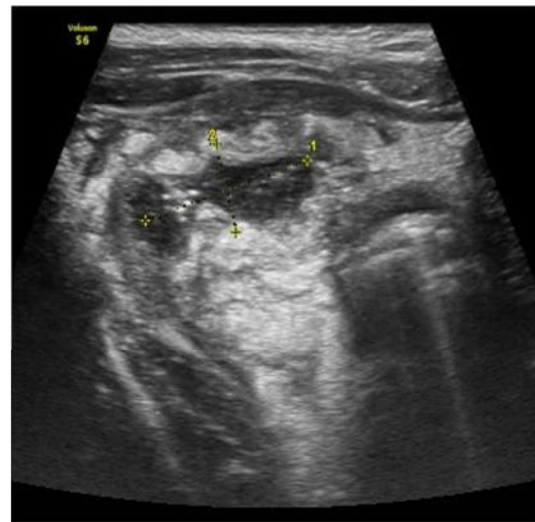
(P,Q).Right lower quadrant Longitudinal & Transverse sonogram shows Acute appendicitis with inflamed surrounding fat & mesentery forming early mass.
